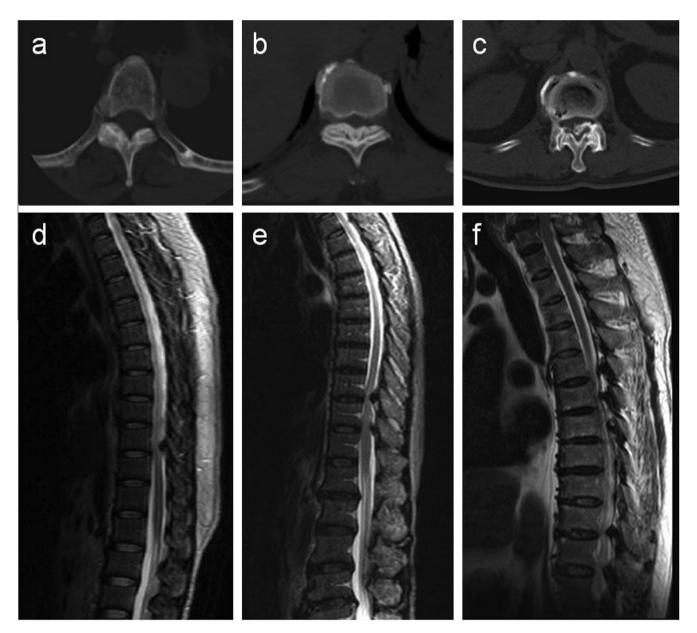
Typical imaging findings of thoracic ossification of the ligamentum flavum. Axial CT images showing (a) lateral type, (b) diffuse type and (c) thickened nodular type configurations of ossified lesions. Sagittal T2-weighted MRI revealing the distribution of (d) isolated type, (e) continuous type and (f) noncontinuous type ossified lesions.
